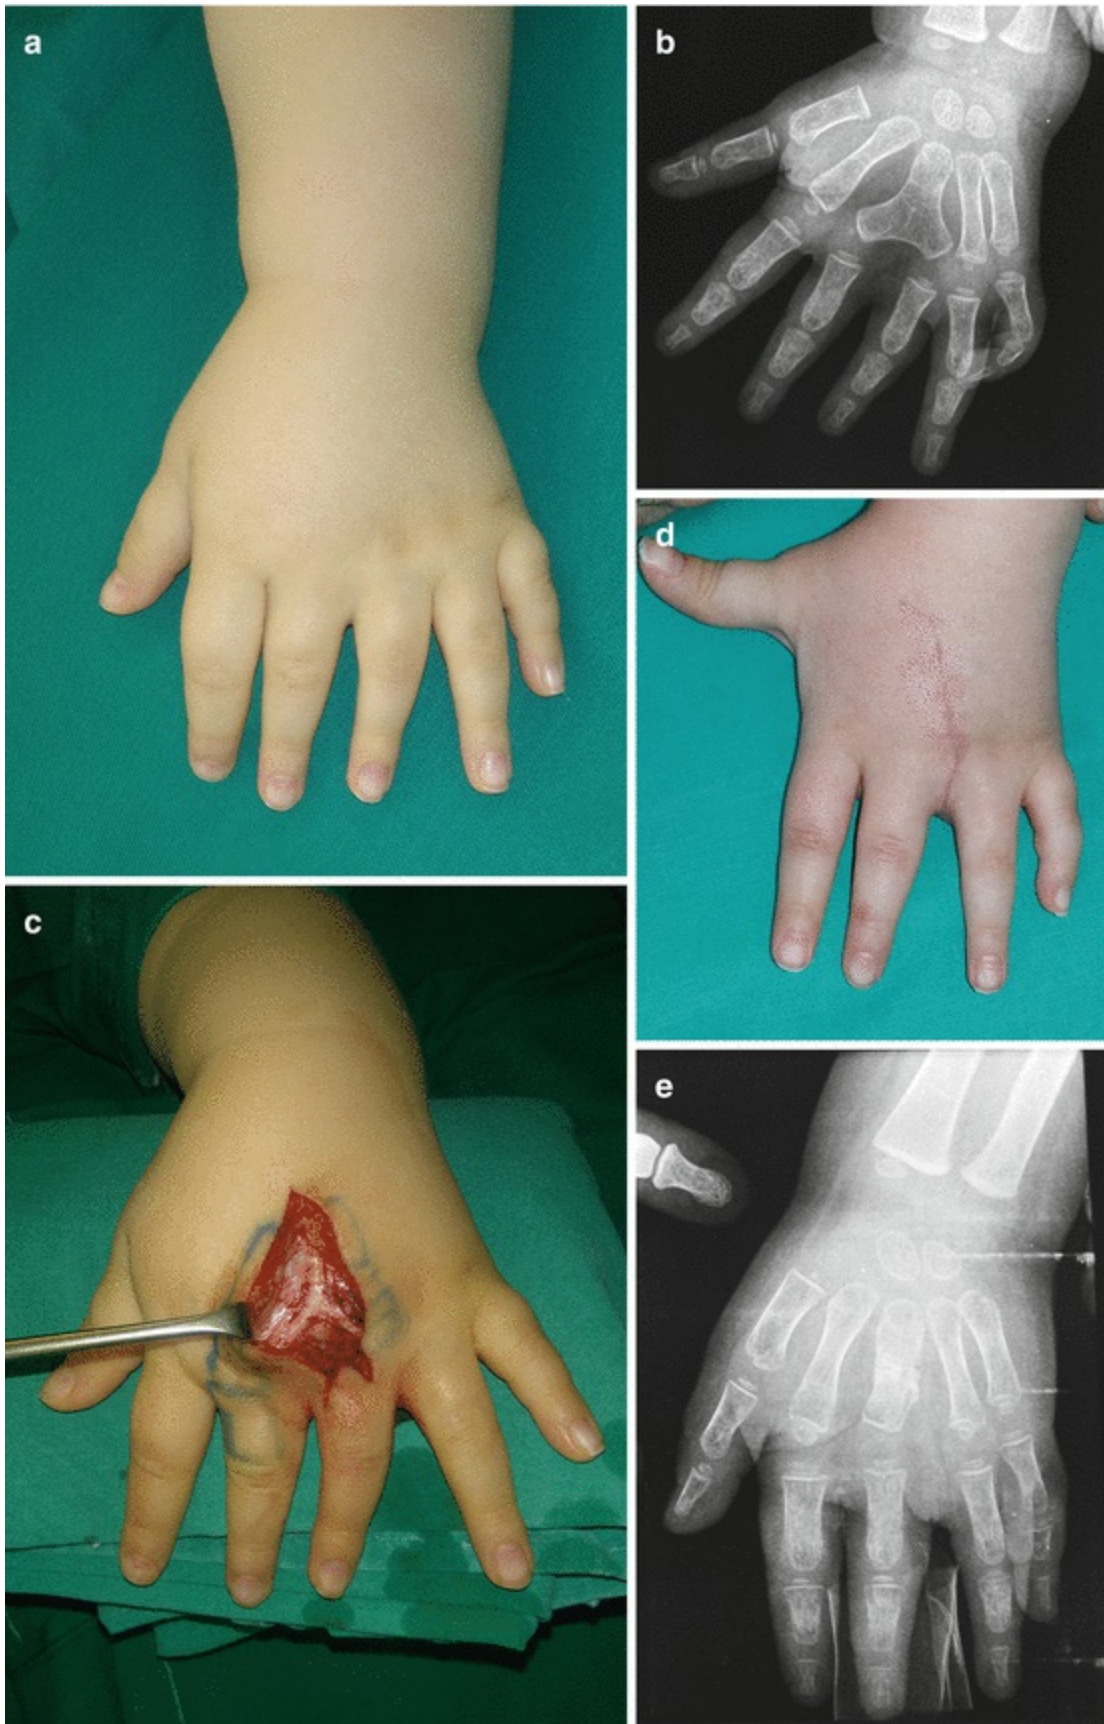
Reconstruction of central polydactyly: (a) preoperative view; (b) preoperative radiography; (c) bifid III metacarpal bone and extensor tendons; (d) postoperative view; (e) postoperative radiography
